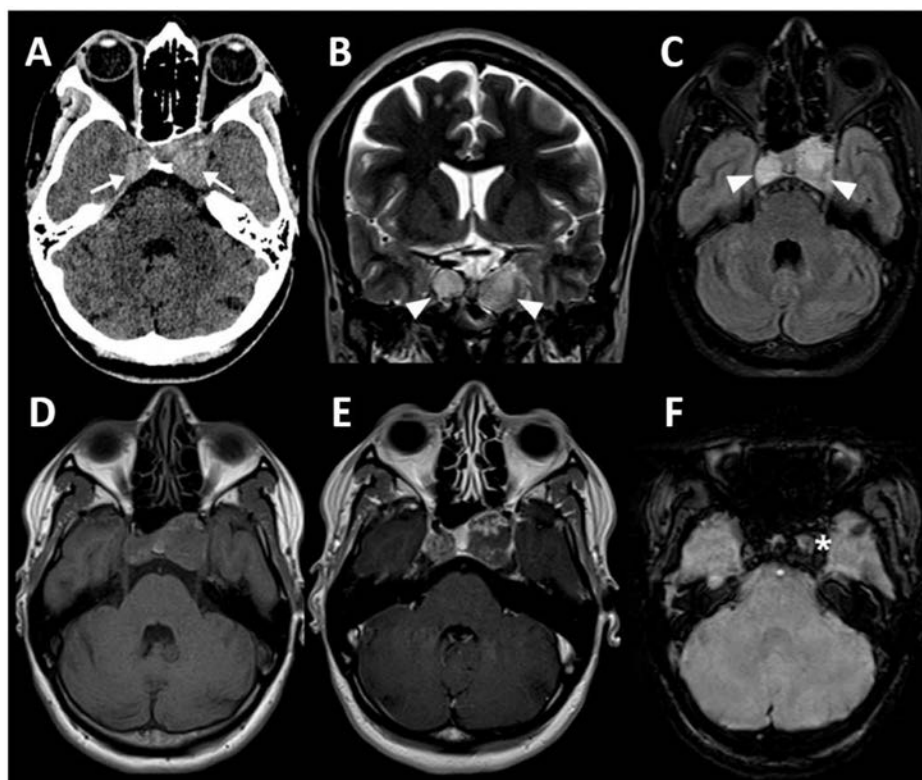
Brain computed tomography and magnetic resonance imaging scans revealing expansile lesions in both cavernous sinuses, hyperdense on CT (white arrows in A), with hyperintensity on T2-weighted and FLAIR sequences (white arrowheads in B and C), showing a reticulated pattern of enhancement (D/E) and blooming effect on SWI (asterisk in F).
